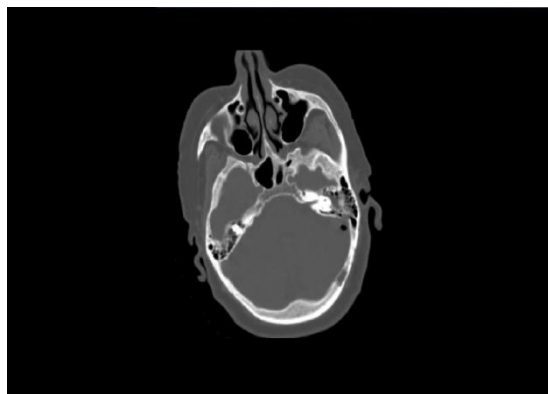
Axial CT image of a middle fossa fracture
